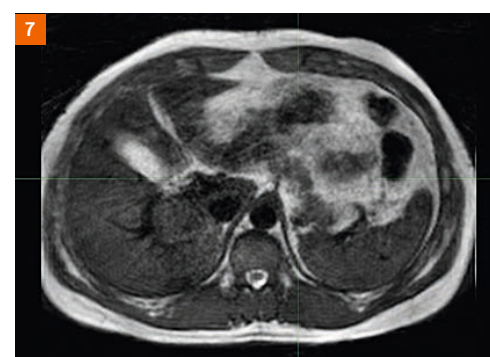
Mixed T2/T1-weighted 4D-MR image of a healthy volunteer acquired using a 4D-MR PSIF acquisition. The increased T2 weighting is evident by the bright CSF signal.
